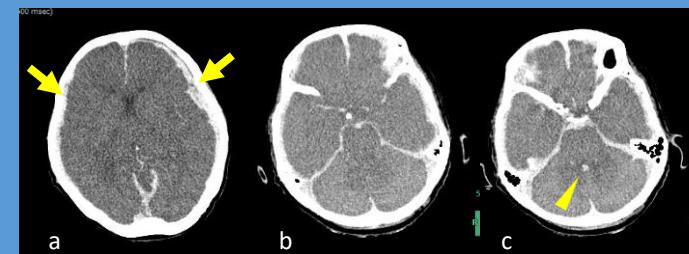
Pre-autopsy computed tomography image. a) Bilateral subdural hematoma (arrow). b) Subarachnoid hemorrhage throughout the basal cistern. c) A small hematoma in the fourth ventricle (arrow head).
